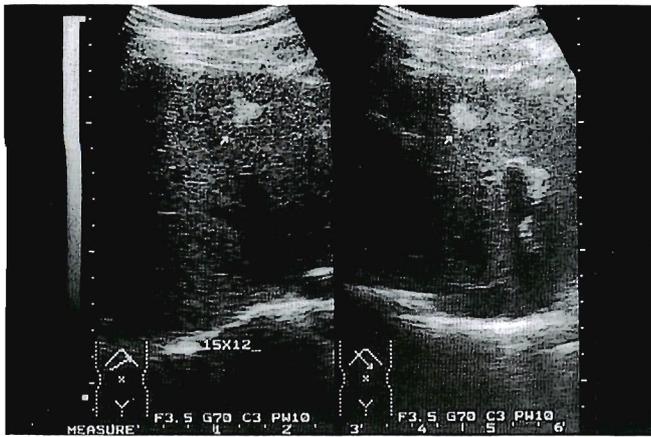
Ultrasonography showing an irregular hyperechoic area lying below the left medial segment (Case 1).
